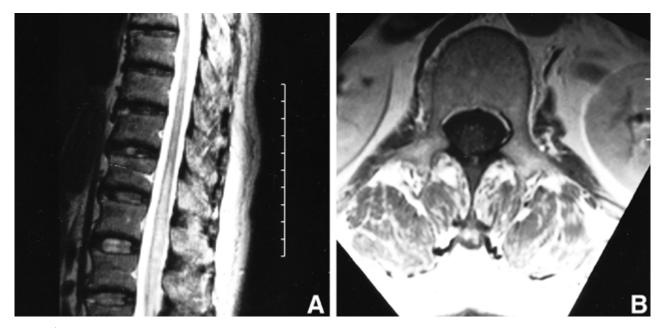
Spinal MRI. (A) T2-weighted sagittal image shows linear high signal intensity with mild cord swelling in T11-L2 level.
